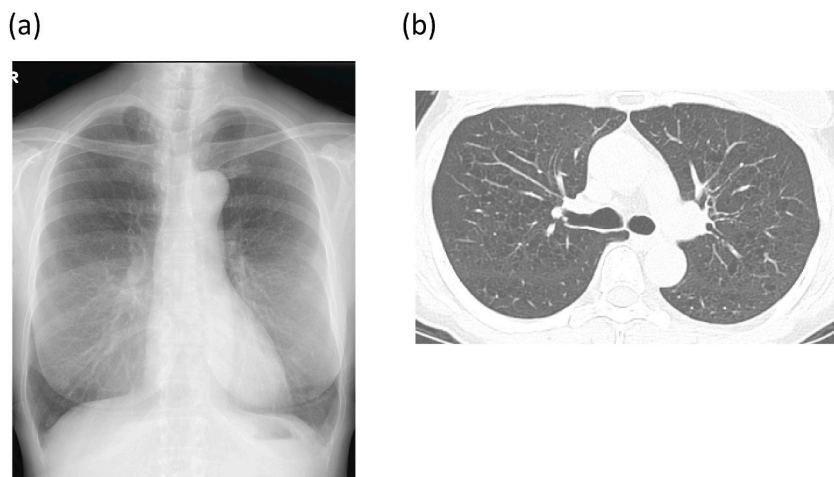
Radiological findings after stopping smoking for one year. (a) Chest radiograph shows indistinct granular shadows predominantly in the upper and middle fields of both lungs. (b) Chest high-resolution computed tomography shows improvement in the thick-walled cysts and granular shadows.
